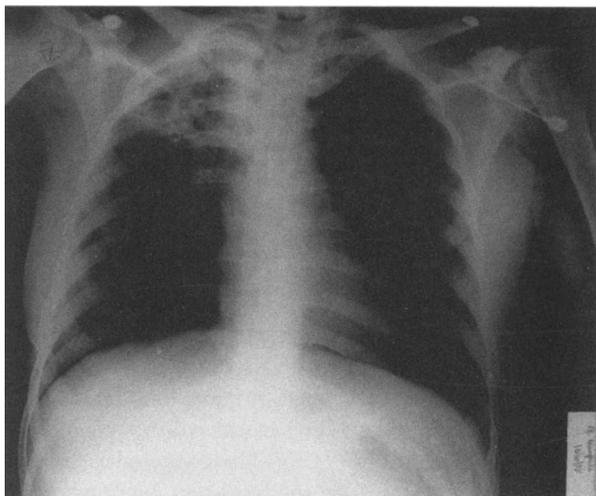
Roentgenogram of the chest showing isolated right upper lobe disease. The patient died of recurrent hemorrhage from the left upper lobe a few hours after emergency lobectomy.
